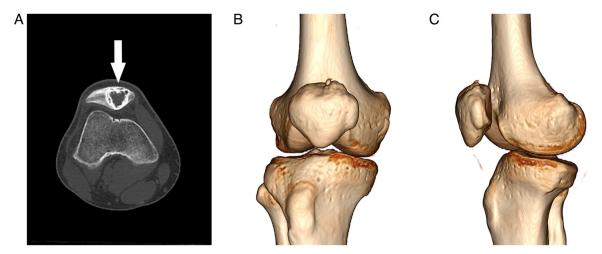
CT scan showing a circular mixed-density image of the right patella surrounded by a thick high-density sclerotic margin with no evidence of extra-articular invasion. (A) Axial plane. (B) Frontal view of three-dimensional CT. (C) Lateral view of three-dimensional CT. CT, computed tomography.
